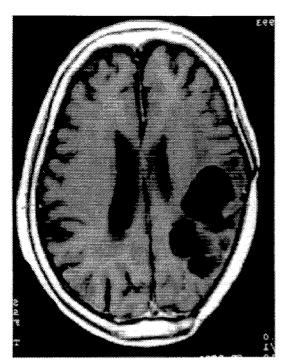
b. Follow up CT 15 years after BNCT
